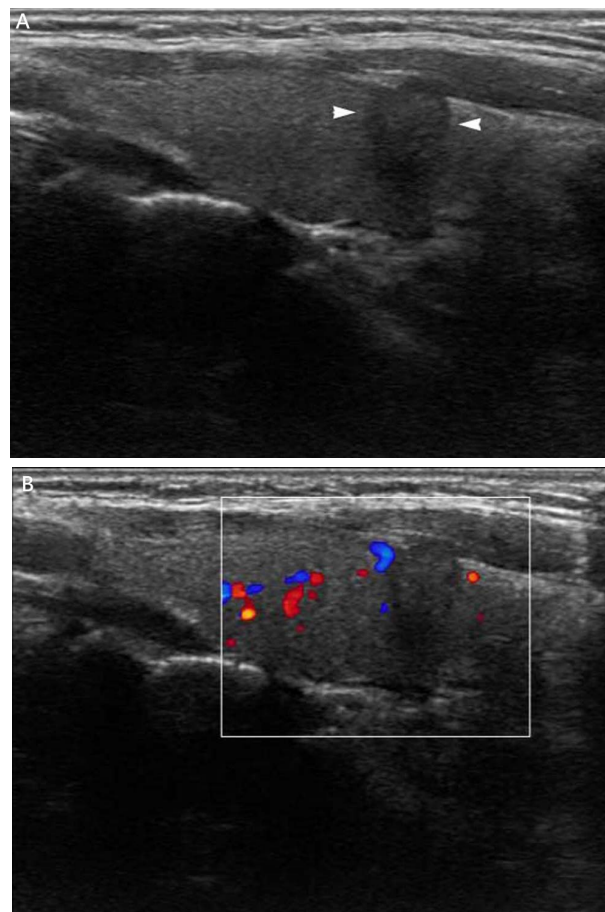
A: A 42-year-old man with solid-type nodule in the right thyroid gland (arrowhead). The tumor size was 7.5x8.3mm and sonographic feature showed spicular margins, “taller than wide” shape and extrathyroid extension. B. Peripheral flows were showed on color Doppler flow imaging (CDFI). The final diagnosis of postoperative pathology was PTC with multiple CLNM
